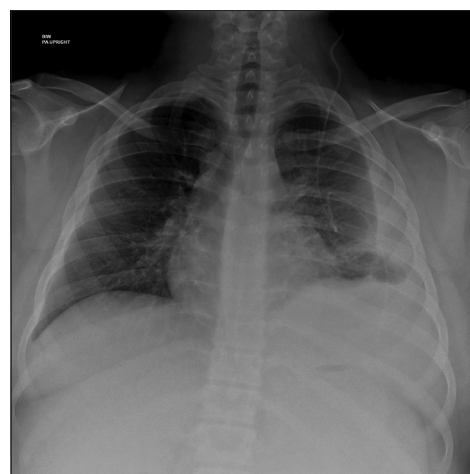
Anteroposterior plain radiograph of the chest depicting a ventriculopleural shunt, left pleural effusion and left basilar atelectasis
